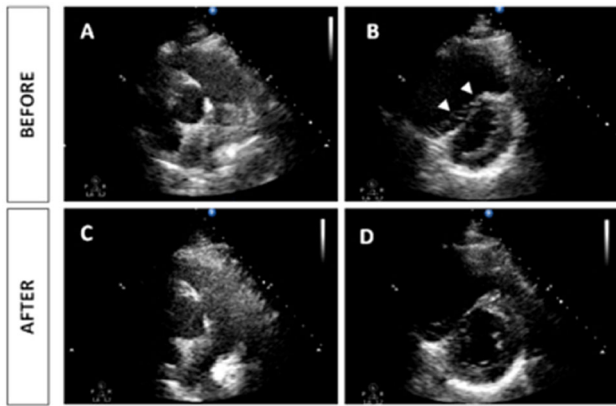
Bedside transthoracic echocardiography in the ICU before and after thrombolysis (parasternal short axis view). A and C: Large and mobile thrombus next to the pulmonary artery bifurcation (A) with dramatic regression after thrombolysis (C). B and D: Systolo-diastolic paradoxical septum motion (white arrows) suggesting a volume and pressure overload of the right ventricle (B). Normalization of the interventricular septum motion after thrombolysis (D)
